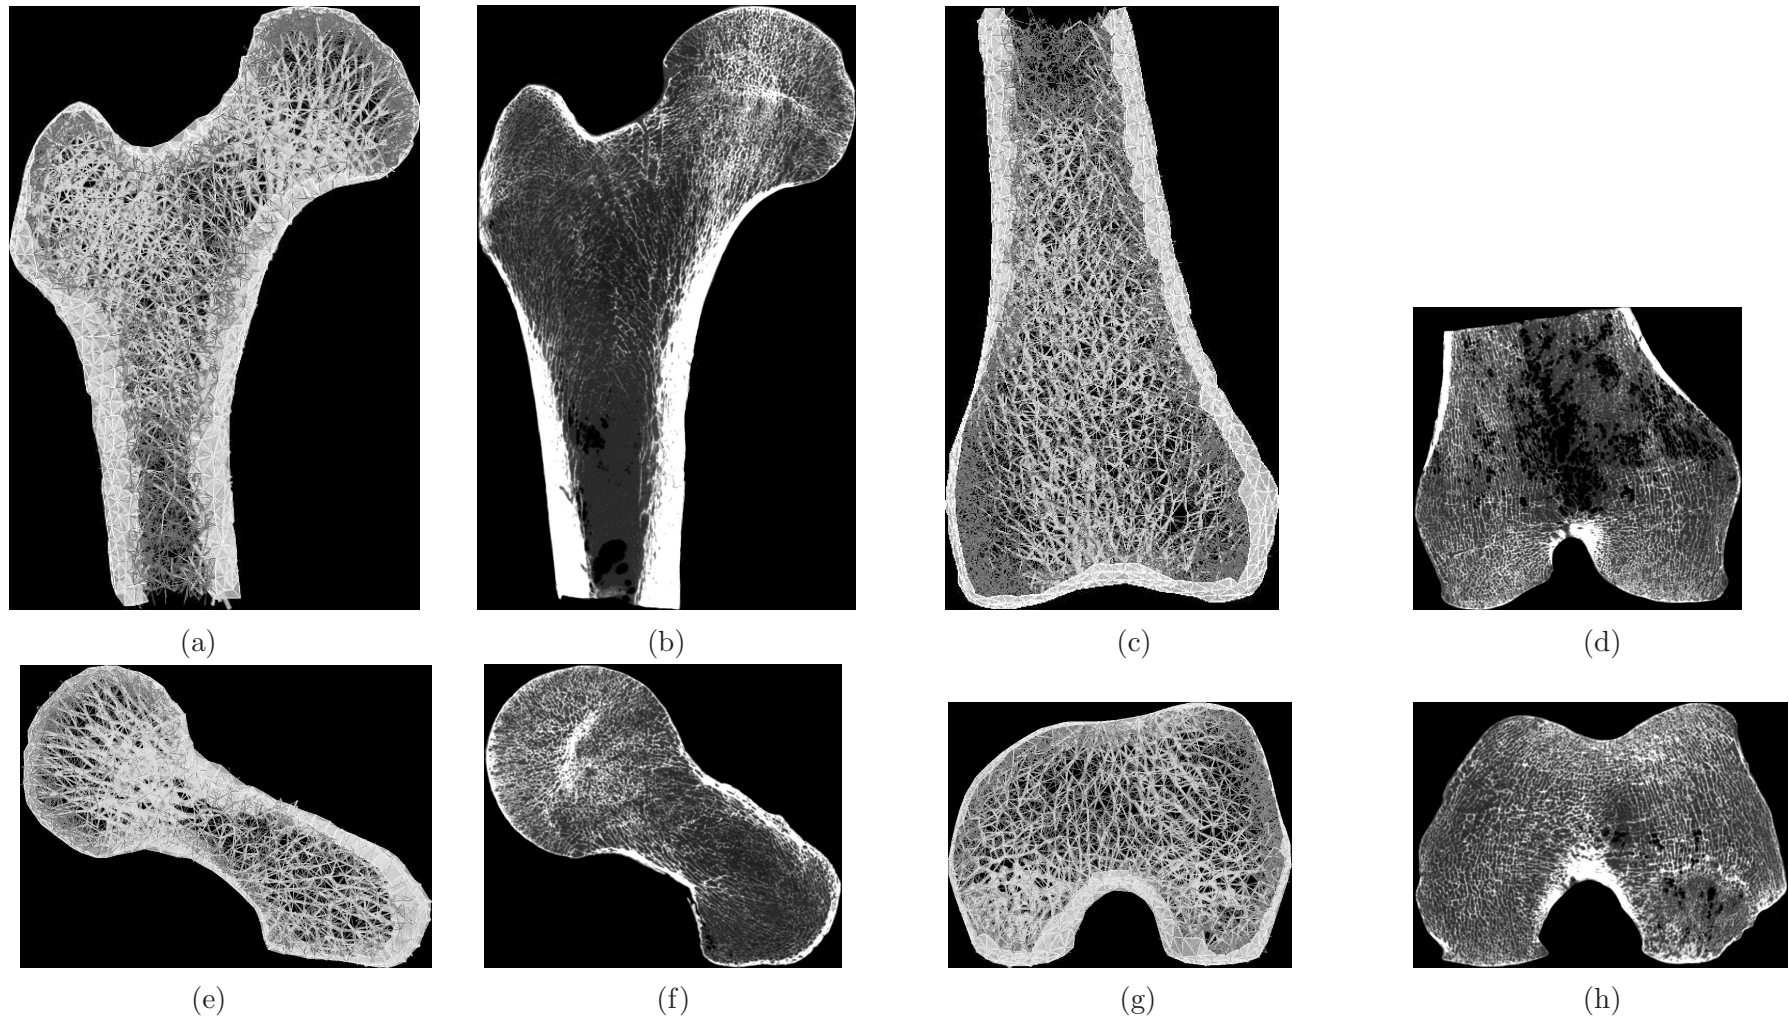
Selected 5mm slices for the altered thickness converged mesoscale structural model subjected to the full loading regime (a, c, e, g), shown alongside corresponding μ CT slices (b, d, f, h). Shell and truss elements with a radius $r > 0.1\text{mm}$ are coloured light grey. Truss elements with a radius $r = 0.1\text{mm}$ are coloured dark grey. Truss elements with a radius $r = 1\mu\text{m}$ are omitted for clarity. All slices are shown as semi-transparent to highlight the structure through the depth of the slice.
